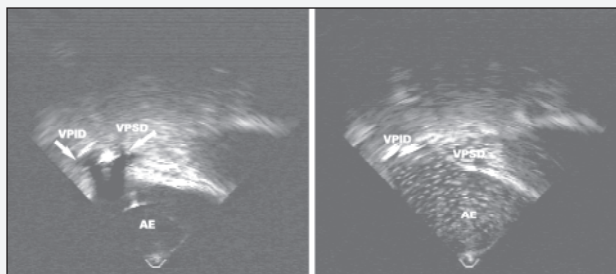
Case # 20 - A) transesophageal study with visualization of the right superior and inferior pulmonary veins (RSPV and RIPV) in a longitudinal view prior to contrast material injection; B) return of the contrast material through the right superior and inferior pulmonary veins, characterizing PAVFs in the entire right lung.
